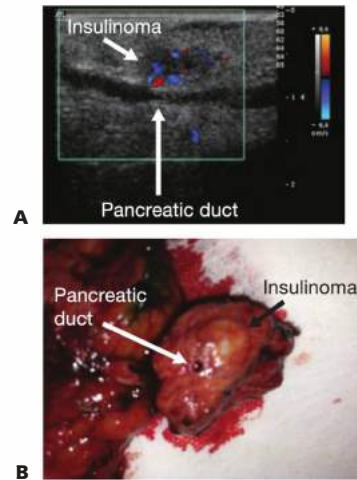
• The patient had a small midbody insulinoma seen by CT scan. Intraoperative ultrasound (A) shows the insulinoma clearly but it indents the main pancreatic duct. Color Doppler ultrasound identifies the duct as there is no blood flow and the insulinoma is hypervascular. Due to the proximity of the main pancreatic duct to the insulinoma, a distal pancreatectomy was performed. B shows the insulinoma bordering a mildly dilated pancreatic duct. If the insulinoma was enucleated, there would be a high likelihood of a significant pancreatic leak.
